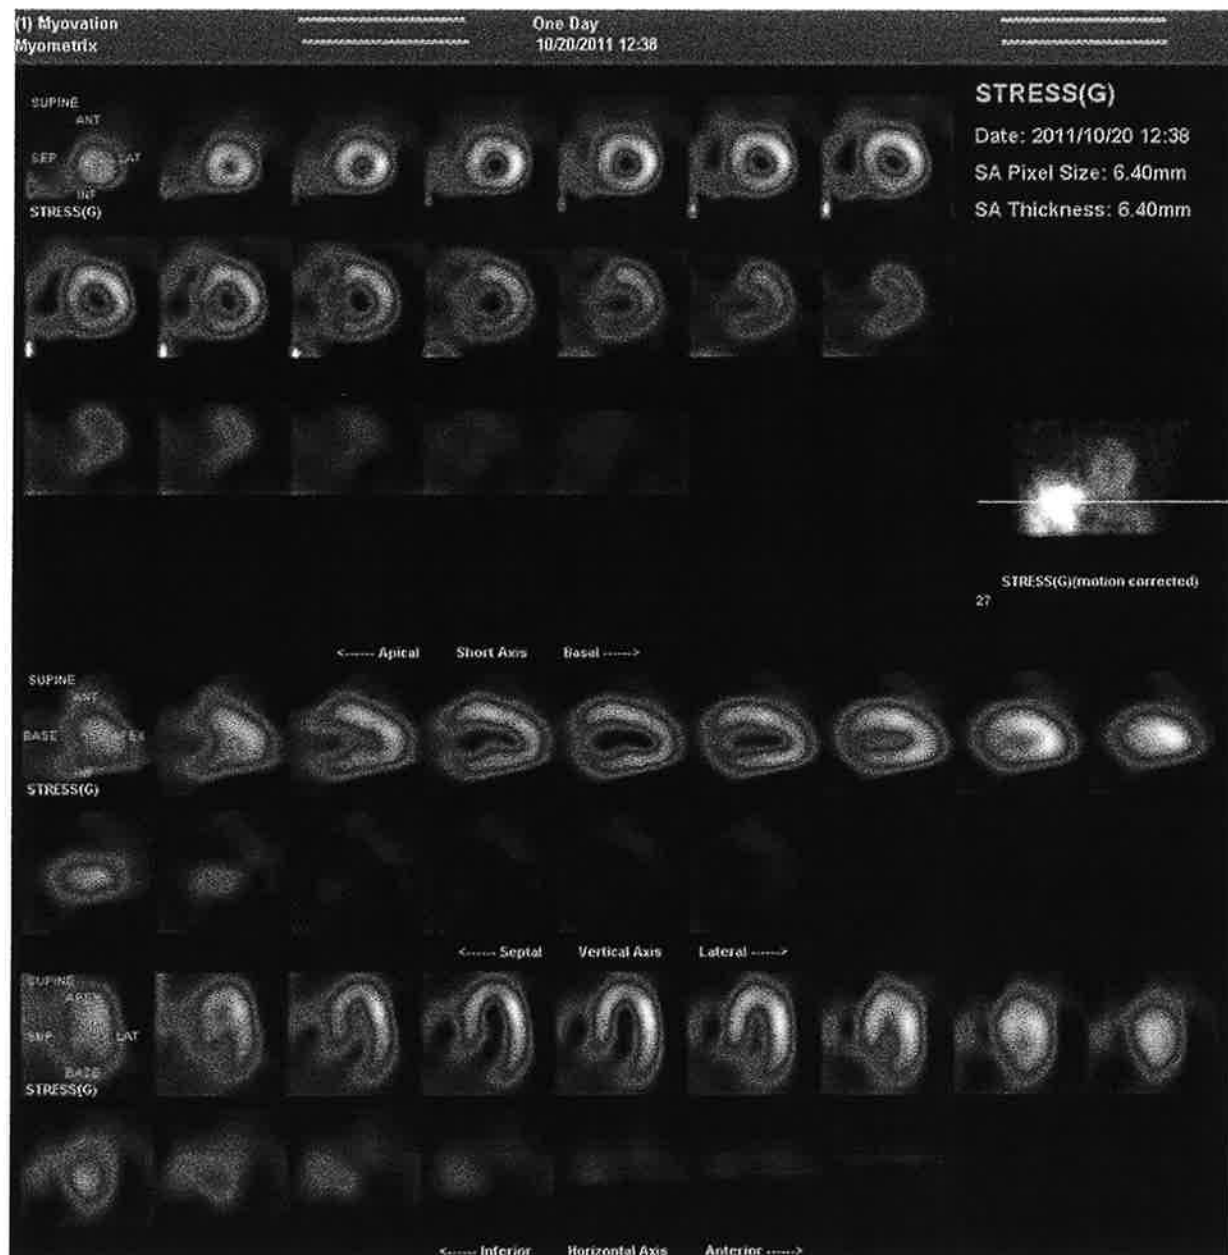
Stress-only myocardial perfusion SPECT was performed using a conventional dual-head NaI detector camera and only a 5 mCi Tc-99m sestamibi dose and a 16-minute acquisition time in this male patient with a 43" chest circumference. Images were reconstructed using WBR Xpress3® "quarter-time" software. Because the SPECT images were unequivocally normal, a subsequent resting scan was unnecessary, thereby markedly decreasing patient radiation exposure. Courtesy Gordon DePuey, St. Luke's-Roosevelt Hospital, New York, NY.
